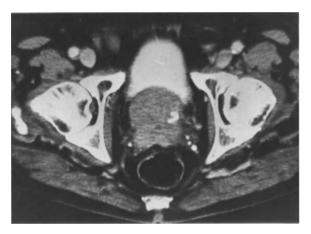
CT of the pelvis. Calcifications of the seminal vesicles in a diabetic patient
